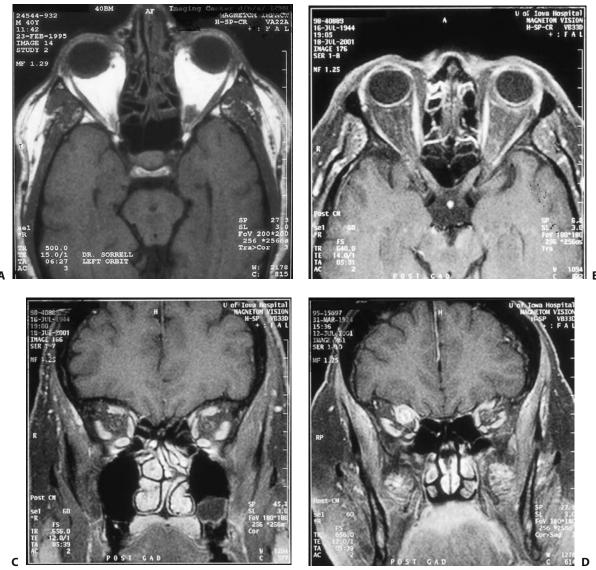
(A) Axial non-fat-suppressed MR images show the hyperintense fat on T1-weighted imaging (B). Axial and (C) coronal MR studies show fat-suppressed postcontrast T1-weighted images.
